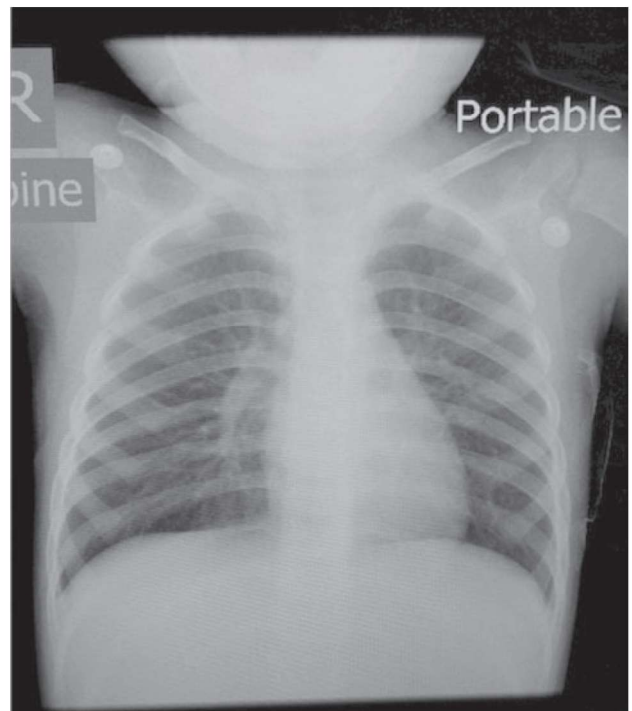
Chest X-ray at discharge, complete resolution of pneumomediastinum and surgical emphysema.
